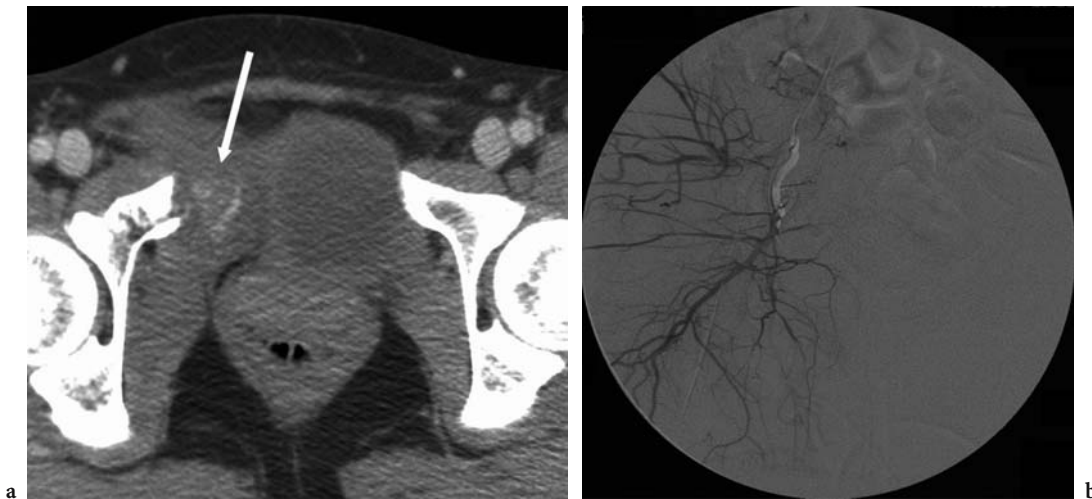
Fifty-year-old female was a restrained driver involved in a road traffic accident traveling at 50 mph. She was hemodynamically stable when the initial pelvic CT was performed. a Contrast-enhanced CT of the pelvis shows right pelvic fractures and active contrast extravasation (*arrow*) with mass effect on the bladder. This finding prompted angiographic study of the internal iliac arteries. b Selective angiogram of the right internal iliac shows no contrast extravasation. As the patient was hemodynamically stable, no embolization was performed.
